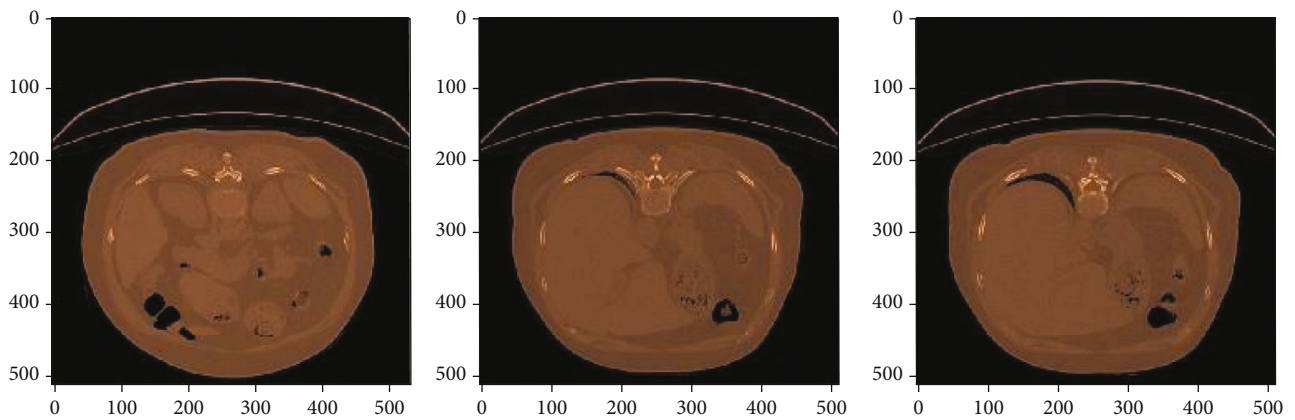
Colormap for CAP-affected chest CT scan images correctly classified by AlexNet+SVM and AlexNet+Random Forest.
